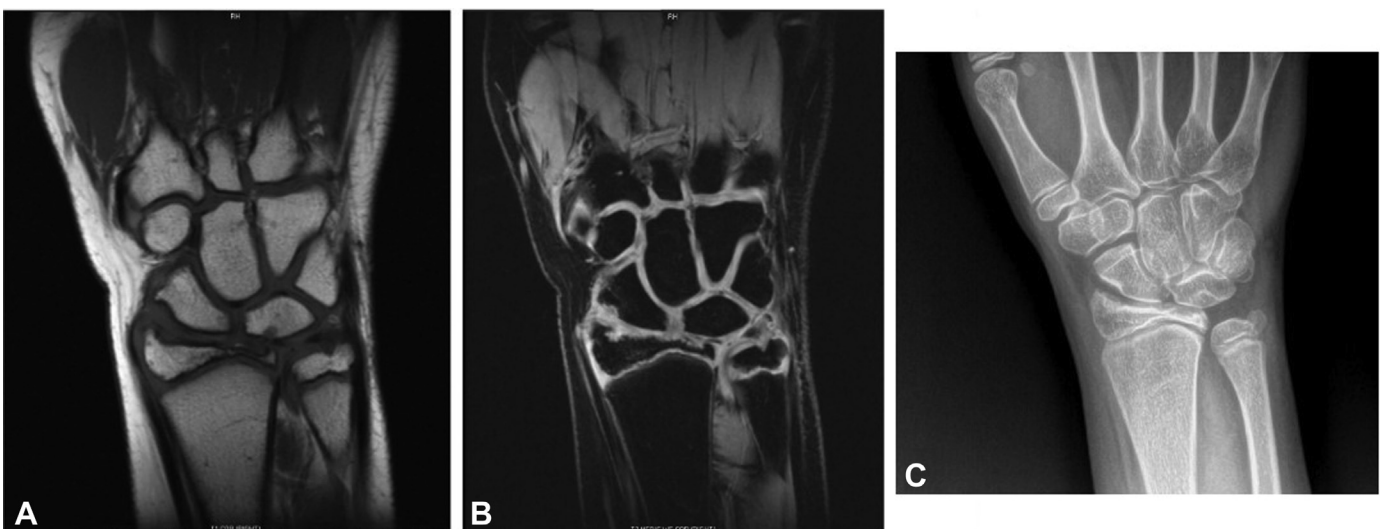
MRI 2 months into therapy revealed continuing resolution of AVN with no collapse or progression, and final radiographs 6 months into therapy demonstrated no acute changes. A T1-weighted wrist MRI. B T2-weighted wrist MRI. C Posteroanterior wrist radiograph.
